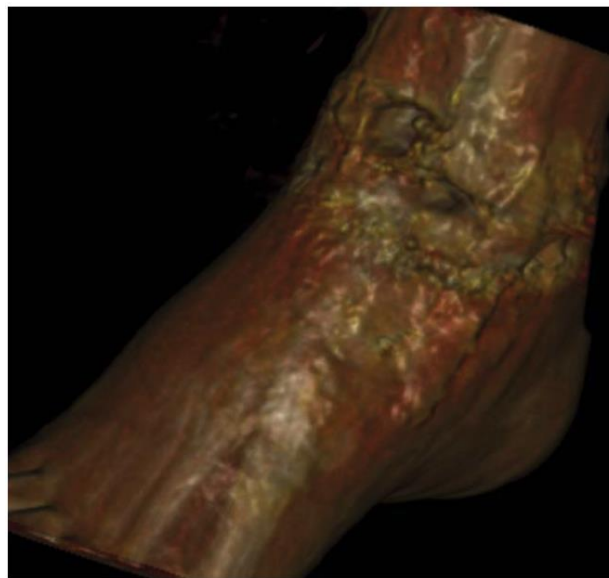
3D reconstructed volume-rendered computed tomography (CT) image of the recipient site demonstrated the soft tissue defect, performed with Osirix software (Pixmeo, Geneva, Switzerland).
